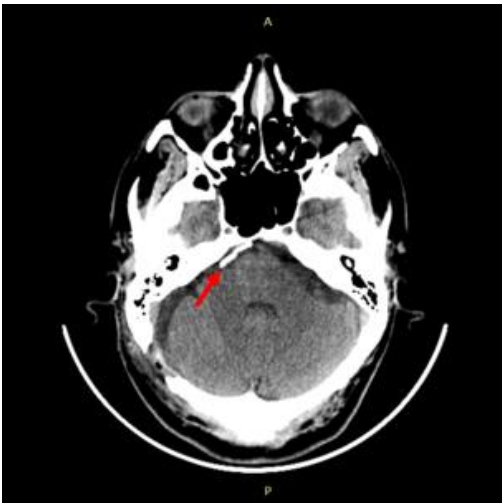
Axial non contrast CT showed hyper dense structure (Teflon) at the right CPA along anatomic course of right trigeminal nerve in 53 year old male status post Microvascular Decompression-MVD surgery.
